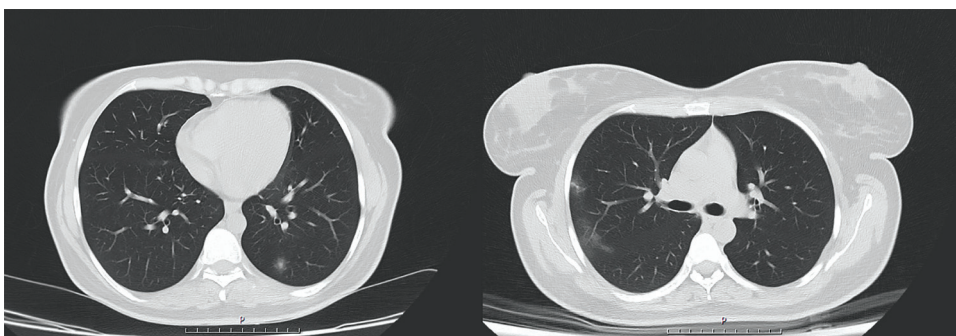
Chest CT imaging shows diffuse bilateral ground-glass opacities with some foci of consolidation formation in the right upper, left, and right lower lobes.
